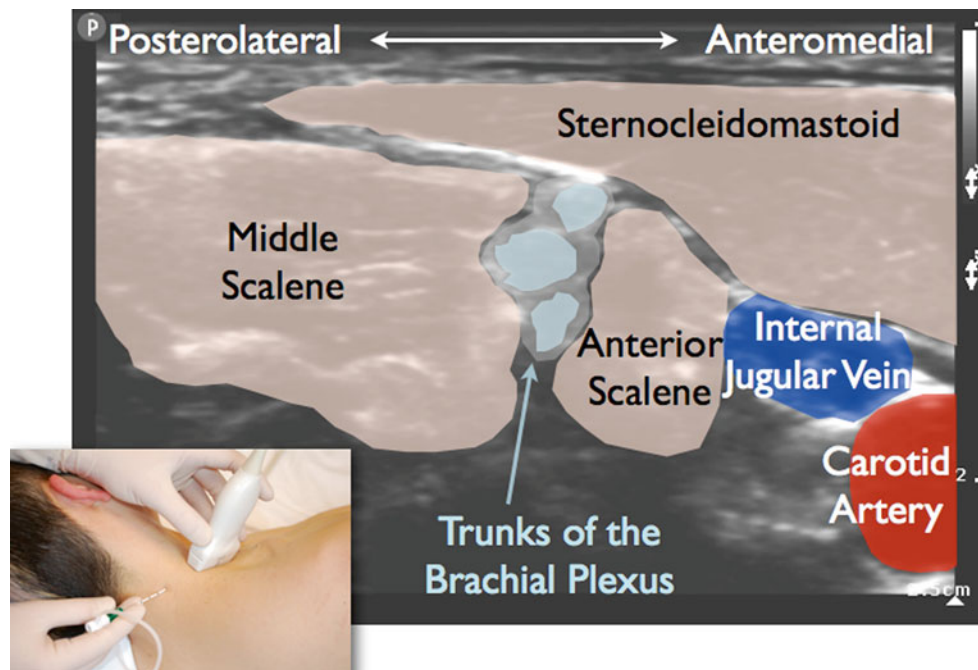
When inserting a continuous interscalene catheter for shoulder surgery, it is desirable to maximize the distance between the needle insertion point and the surgical site (The inset figure showed the position of the ultrasound probe and the direction of the needle insertion)
